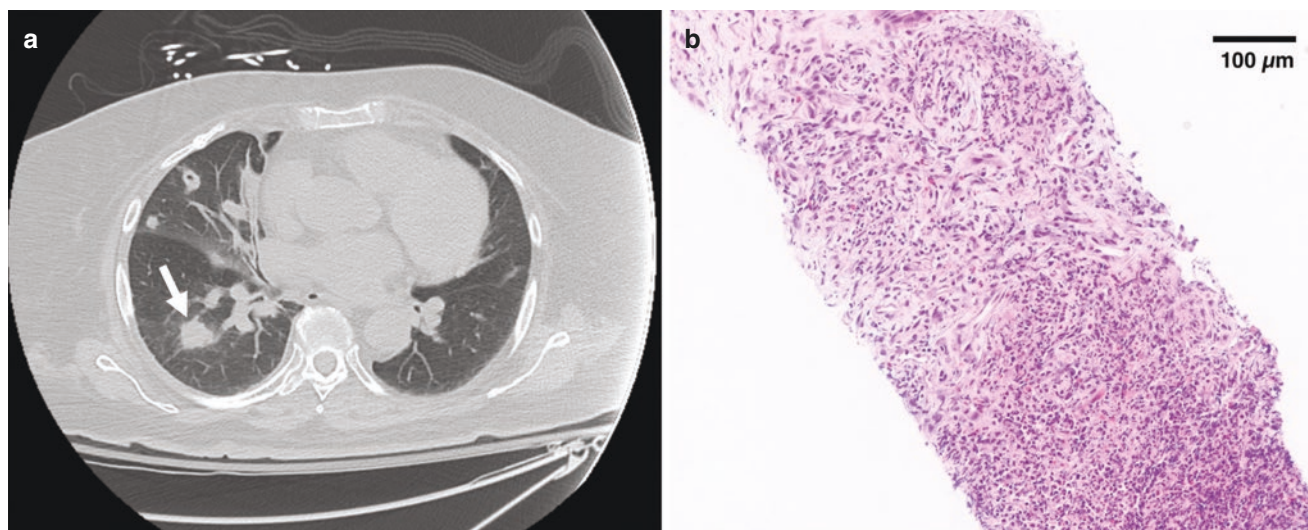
Radiographic and biopsy findings from case presentation. (a) Computed tomography (CT) scan demonstrating a 2.1-cm cavitary lesion in lower lobe of the right lung (arrow). (b) Core needle biopsy
